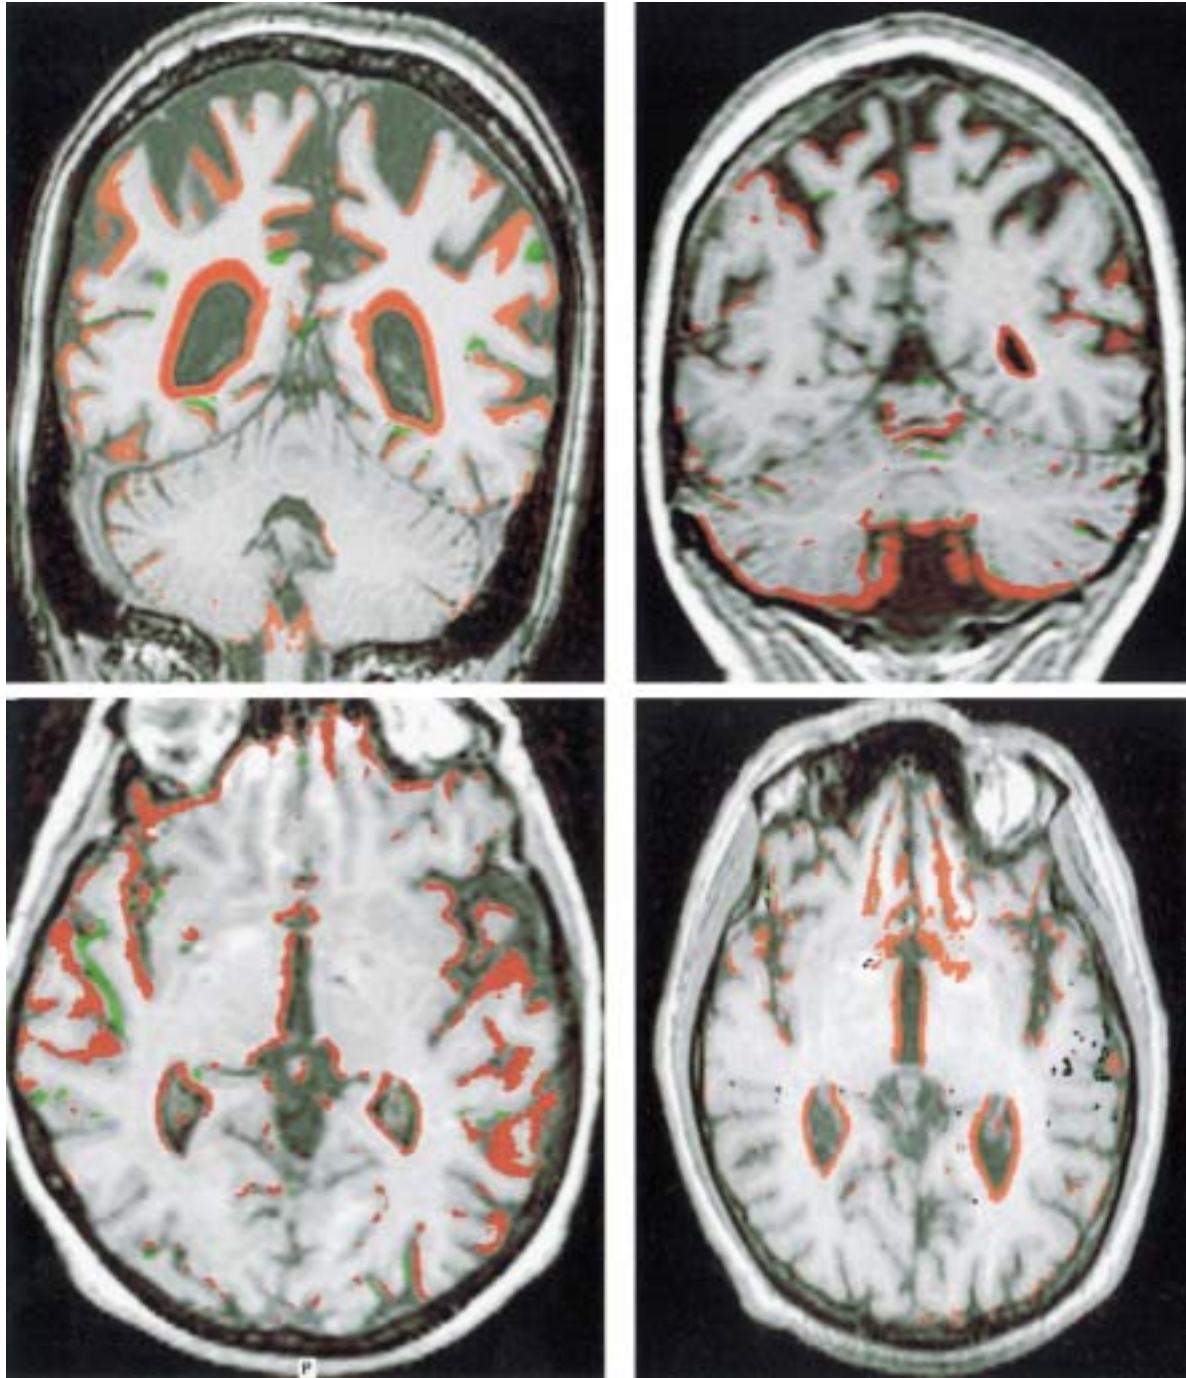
Subtraction of time series can be performed after accurate image registration to show subtle changes over time that can be difficult to appreciate by visual inspection. Shown are coronal images from T1-weighted 3D data sets
